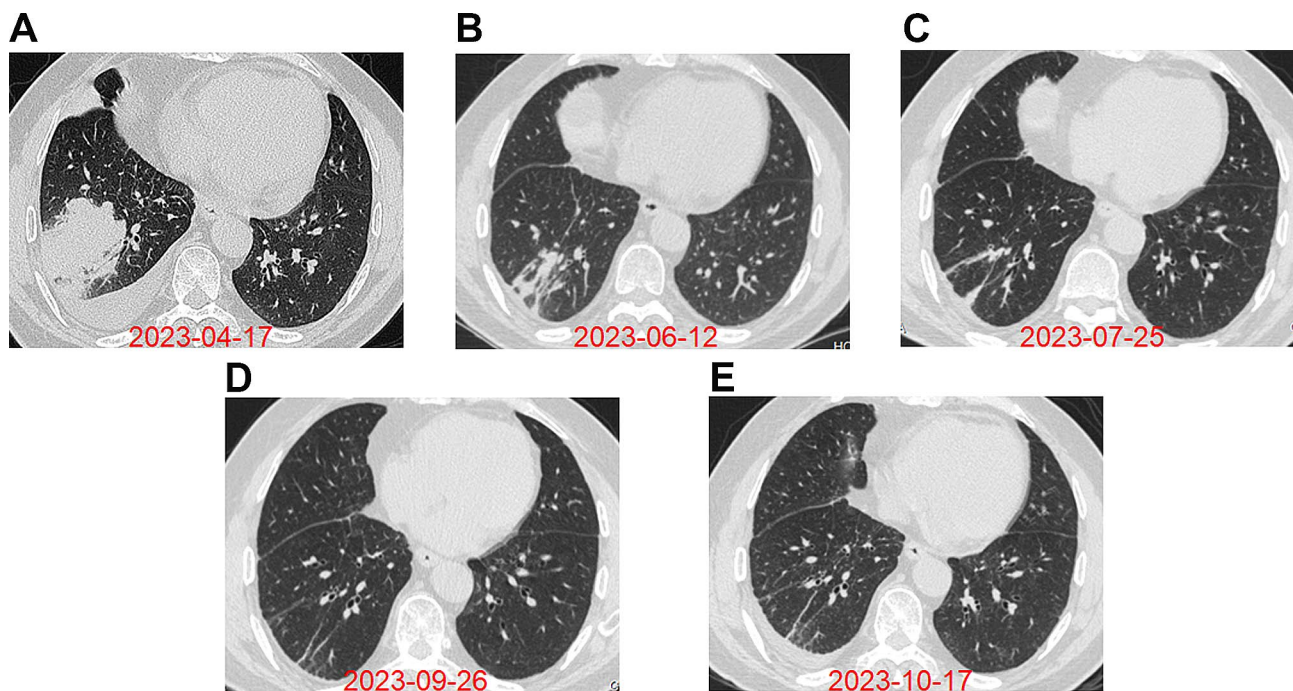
Comparison of chest CT scans pre- and post-treatment with savolitinib: (A) Initial chest CT scan prior to the administration of savolitinib, showing the primary tumor mass and any potential signs of metastasis. (B) CT scan results after the commencement of savolitinib treatment, highlighting the notable decrease in tumor size and the absence of tumor progression or spread. (C) CT scan after three months, showing continued tumor reduction. (D) CT scan after five months, showing stable disease. (E) CT scan after six months, showing further tumor reduction with no new lesions
